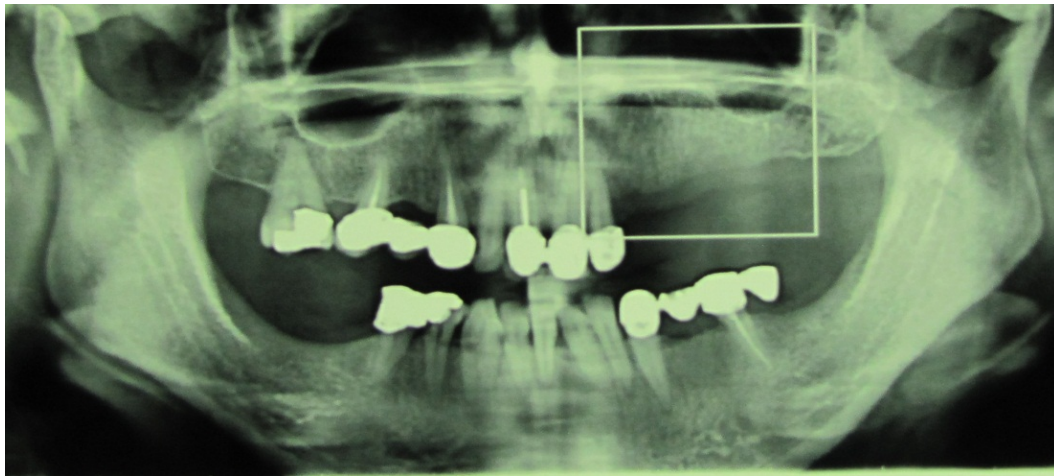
Pre-operative radiograph of the left posterior edentulous maxilla
